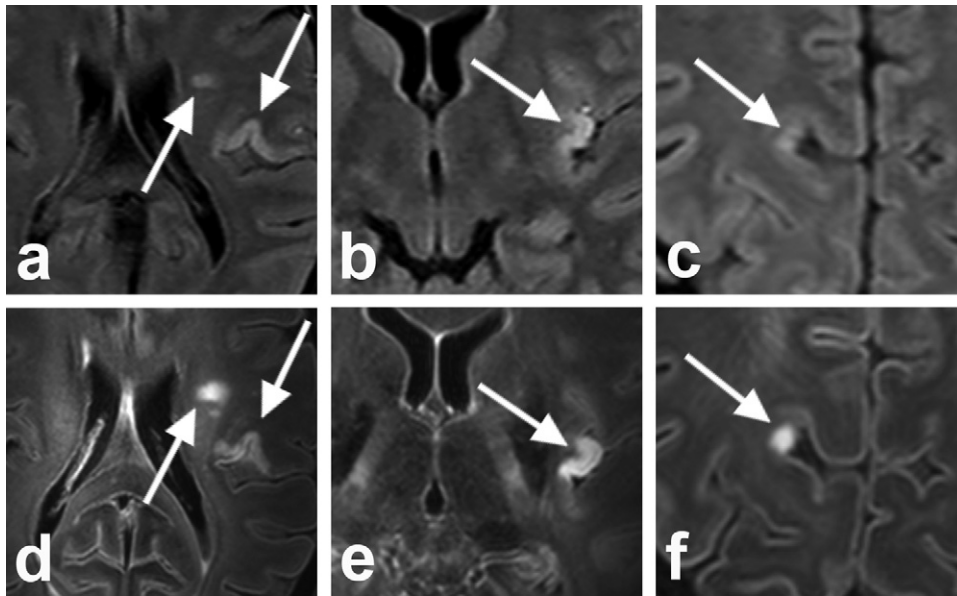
40-year-old female with a history of systemic lupus erythematosus (SLE) presented with thrombotic thrombocytopenic purpura (TTP) complicated by transient motor dysphasia. a–c, Axial standard clinical 1.5 T and d–f, corresponding 7 T MRI FLAIR images, showing several small cortical and subcortical hyperintense ischemic lesions (arrows). Due to the higher contrast-to-noise ratio at 7 T, lesions were more conspicuous than at lower field strength, and some were seen only in retrospect at 1.5 T (arrow in c, compared to f). Imaging parameters as previously published [3], 0.8 mm isotropic resolution.
